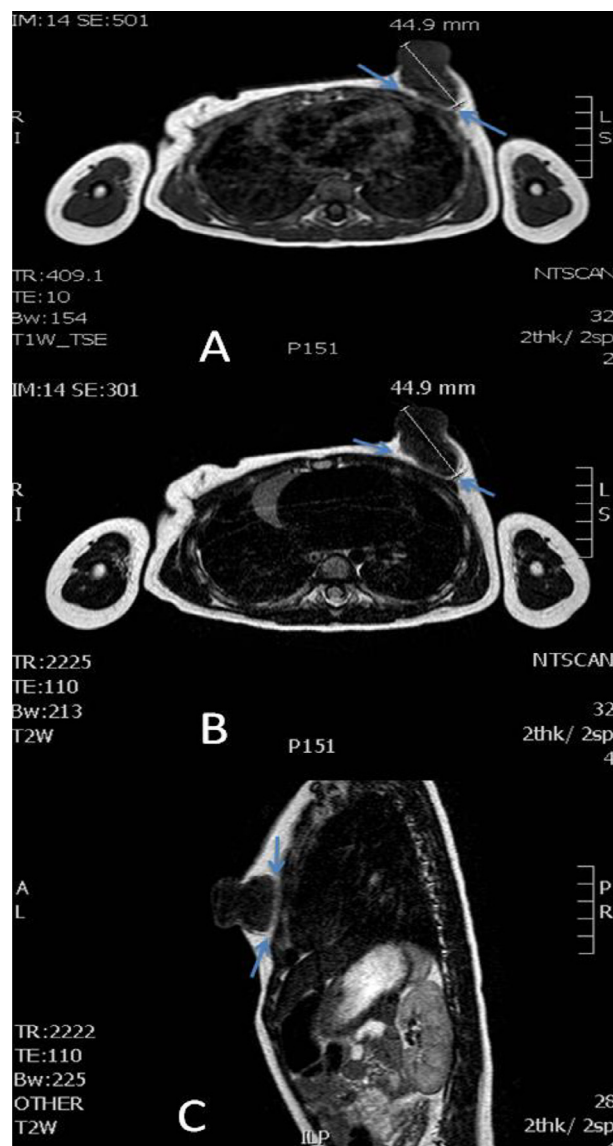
MRI with (A) axial T1, (B) axial T2 and (C) sagittal T2 sequences shows a solitary well-circumscribed lesion of 4.5 cm in the left breast, isointense compared to the muscular structures. without invasion of the pectoral muscle. A thin hyperintense line between the lesion and the pectoral muscle on T1- and T2-weighted images (blue arrows) corresponds to fatty tissue, thus no infiltration of the underlying pectoral muscle. (Color version of figure is available online.)
